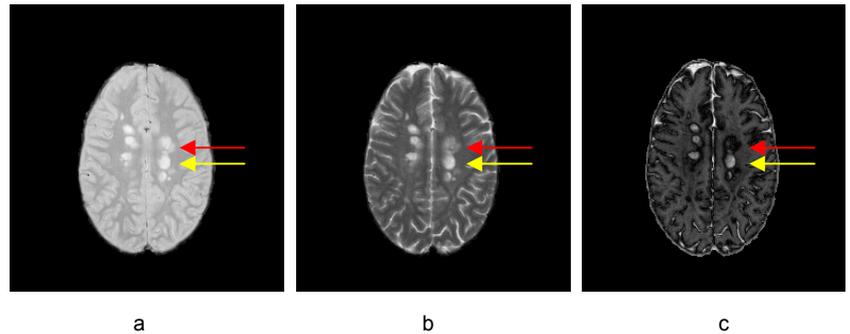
a) A PD-weighted image with the corresponding b) T2-weighted image and c) ADIMA image. The yellow arrow shows the same “hyperintense” MS lesion across all image types whereas the red arrow shows “hyper-” and “hypo-” intense areas of heterogeneity in the ADIMA image which are not well defined from the PD and T2 weighted images alone.
